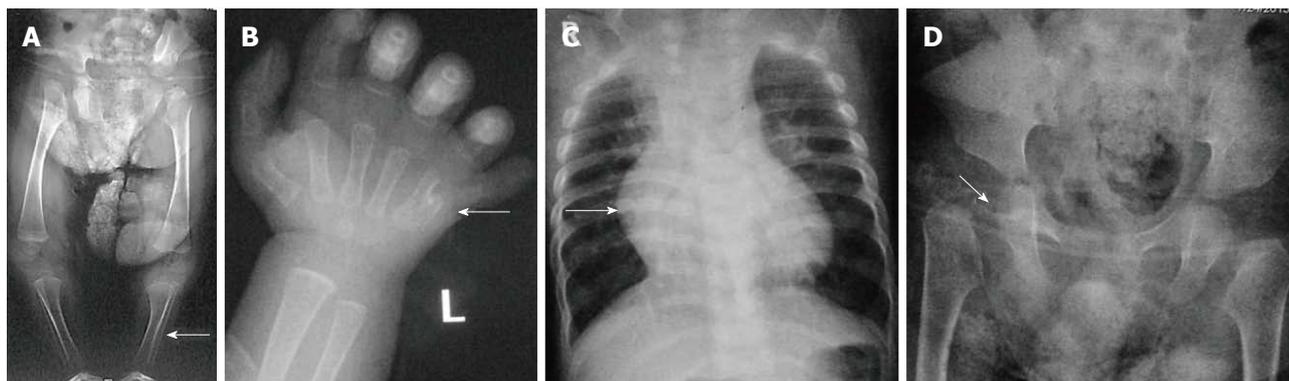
Chondroectodermal Dysplasia (Ellis Van-Creveld Syndrome). Multiple radiographs of patient with chondroectodermal dysplasia show mesomelia (arrow, A), polydactyly on ulnar aspect with fused metacarpals (arrow, B), cardiomegaly with right side enlargement due to atrial septal defect (arrow, C) and acetabular hook (arrow, D). Also note flared iliac wings in pelvis.
